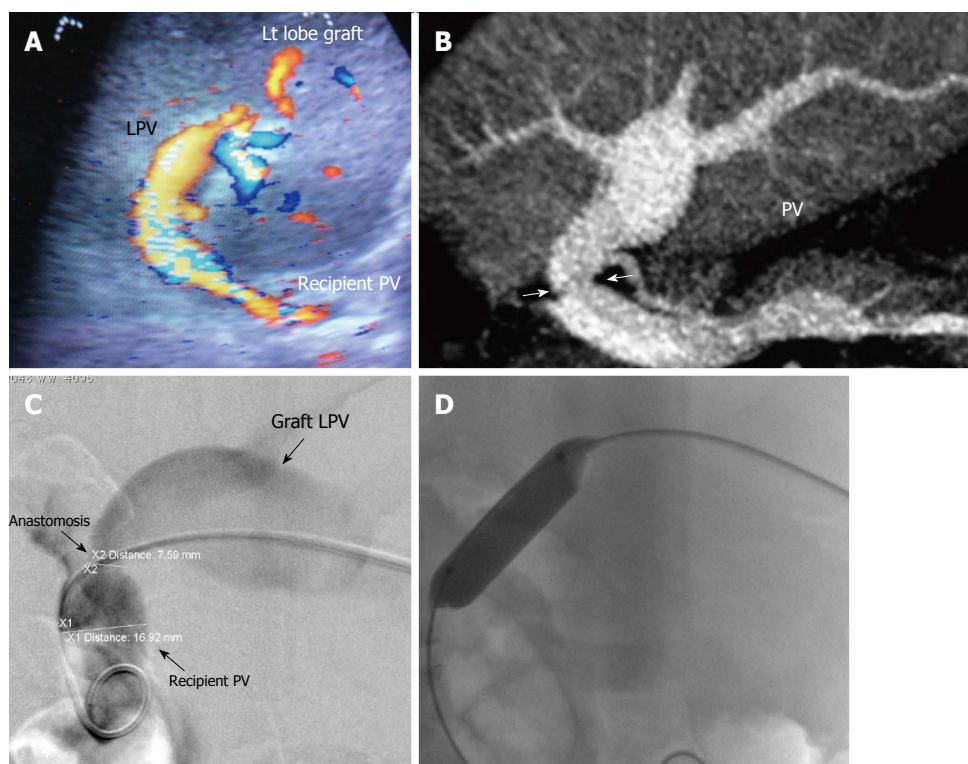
Post-operative developmental portal vein stenosis in a 16-year-old boy with progressive splenomegaly and pancytopenia, 1-year post-left lobe living donor liver transplantation. A: Color US image showing PV anastomotic stricture and post-stenotic dilatation. The anastomotic velocity elevation was borderline (3–4-fold) compared to the pre-anastomotic velocity (not shown); B: Multi-slice CT angiography, reconstructed image, demonstrating moderate PV anastomotic stricture with post stenotic dilatation of the graft PV; C: Percutaneous trans-hepatic digital subtraction portography image, demonstrating moderate PV anastomotic stricture (> 50 %) with post-stenotic dilatation. The pressure gradient was 7 mmHg; D: X-ray image during balloon dilatation of the stricture. The pressure gradient was normalized and stent placement was not performed. PV: Portal vein; LPV: Left portal vein.
